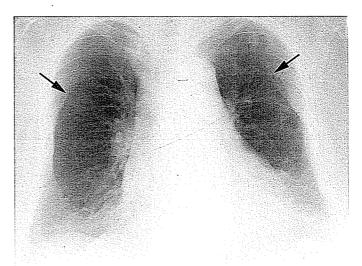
Extrapleural fat in a patient treated with steroids. Chest radiograph shows lobulated smooth thickening along the chest wall bilaterally, extending to the lung apices, and extending. Symmetric curvilinear interfaces in the upper chest (arrows) are due to invagination of fat into the major fissures bilaterally.
